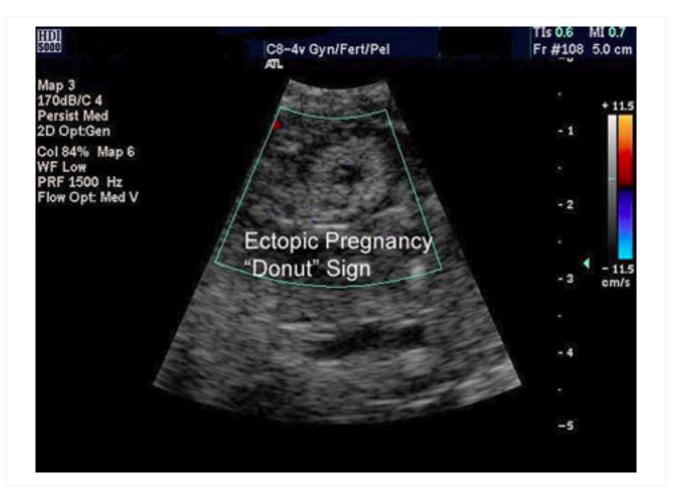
Ectopic pregnancy: Ultrasound image of ectopic pregnancy showing the donut sign
